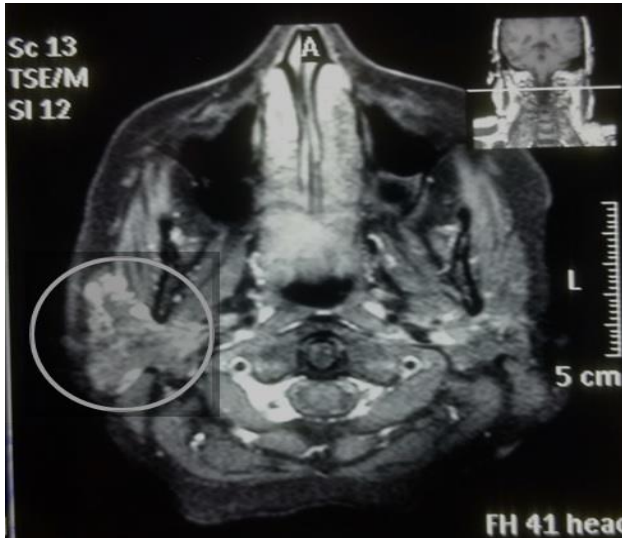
T2 weighted fat suppressed MRI showing Right parotid enlargement with multiple tubular enhancing structures traversing through the superficial lobe of right parotid gland.
